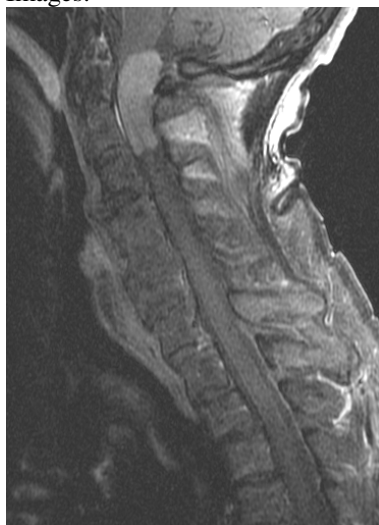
Contrast enhanced MRI of the cervical spine in a myelopathic patient with an implanted pacemaker. The enhancing intradural extramedullary mass at the craniocervical junction was shown to represent meningioma. This was not detected on an outside CT myelogram. However, the diagnosis is readily made with MRI.
